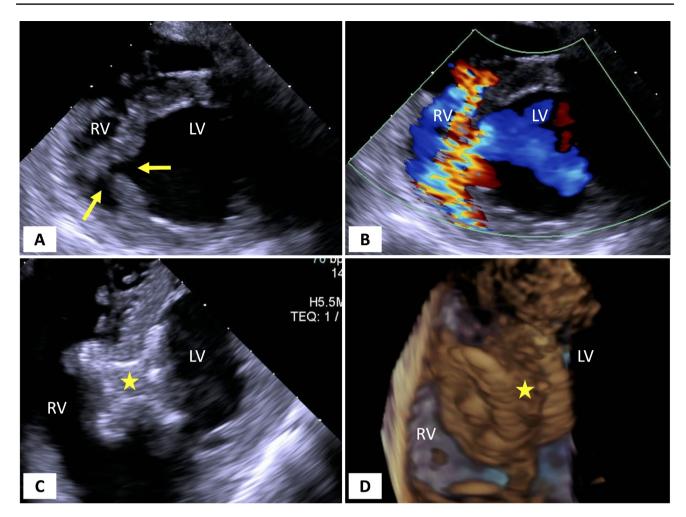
A, B Transesophageal echocardiography demonstrating a simple ventricular septal rupture (*yellow arrows*) with left-to-right flow by color Doppler. C, D Percutaneous closure with a 24-mm
